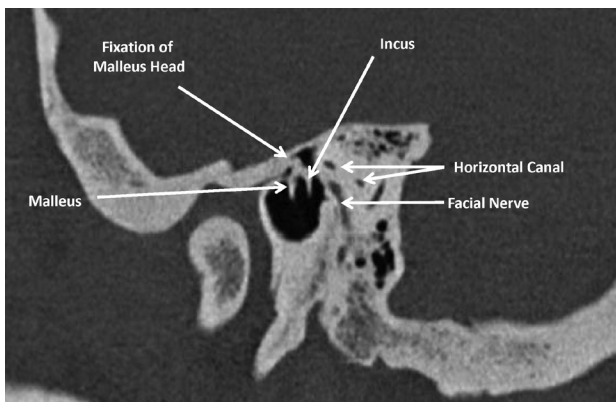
The sagittal CT image of the left temporal bone at the level of the malleus and incus demonstrated fixation of the malleus head to the epitympanic (attic) wall.
